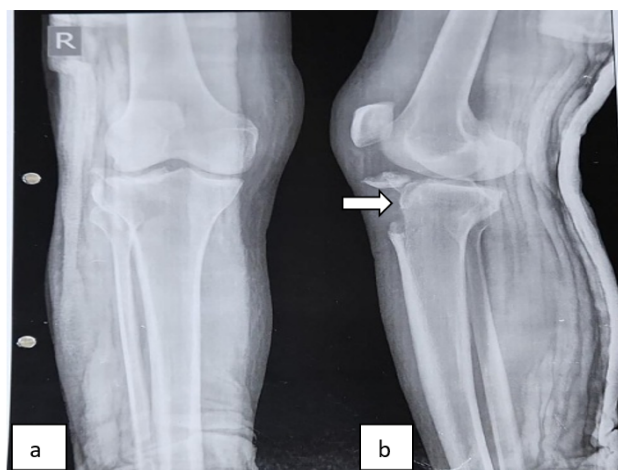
a): Anteroposterior and b): Lateral radiographs of right knee
